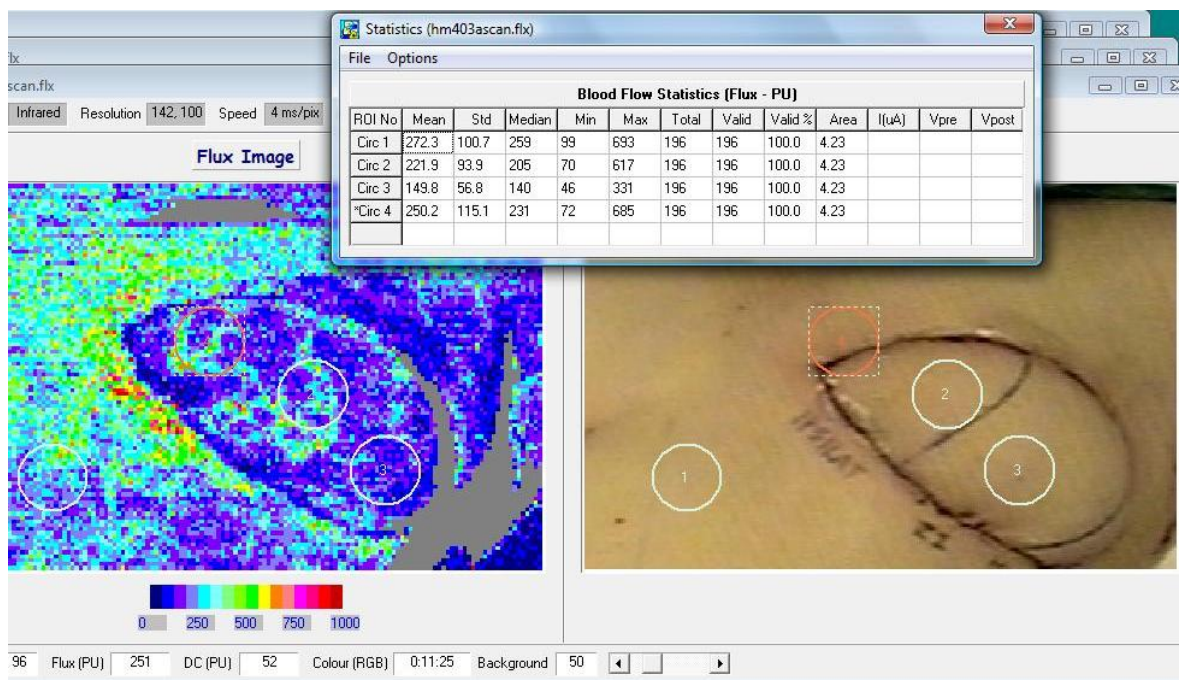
Laser Doppler image of patient 4 from above.
